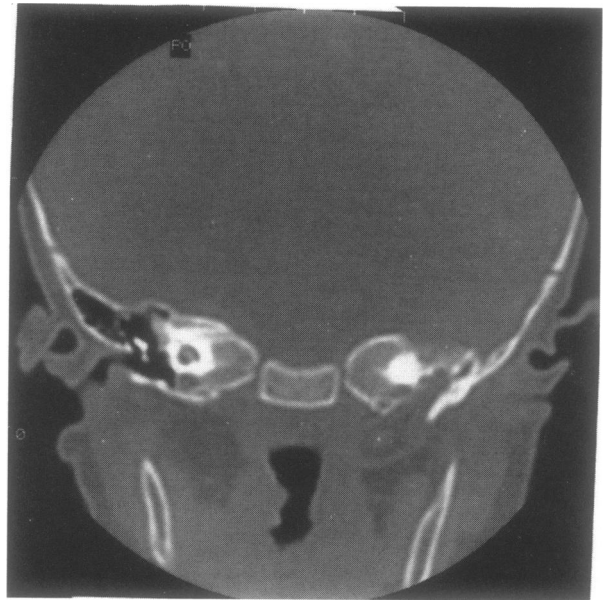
Coronal CT demonstrating proximal eustachian tube expansion.
